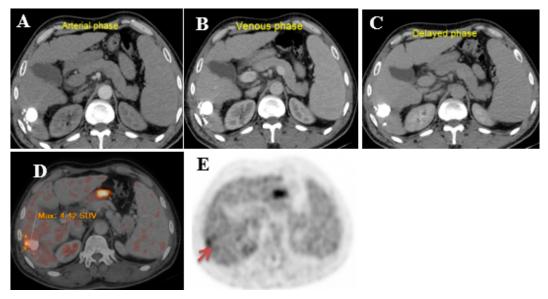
Fifty seven years old male patient with history of chemo-embolization for hepatic focal lesions, presented with elevated alpha fetoprotein. A,B,C CECT phases show no abnormality with good lipiodol concentration however at D fused PET/CT image, there is focal increase FDG uptake at the periphery of the embolized lesion at segment VI. E Axial CTAC image showing the focal FDG uptake around the emoblized lesion (red arrow).
